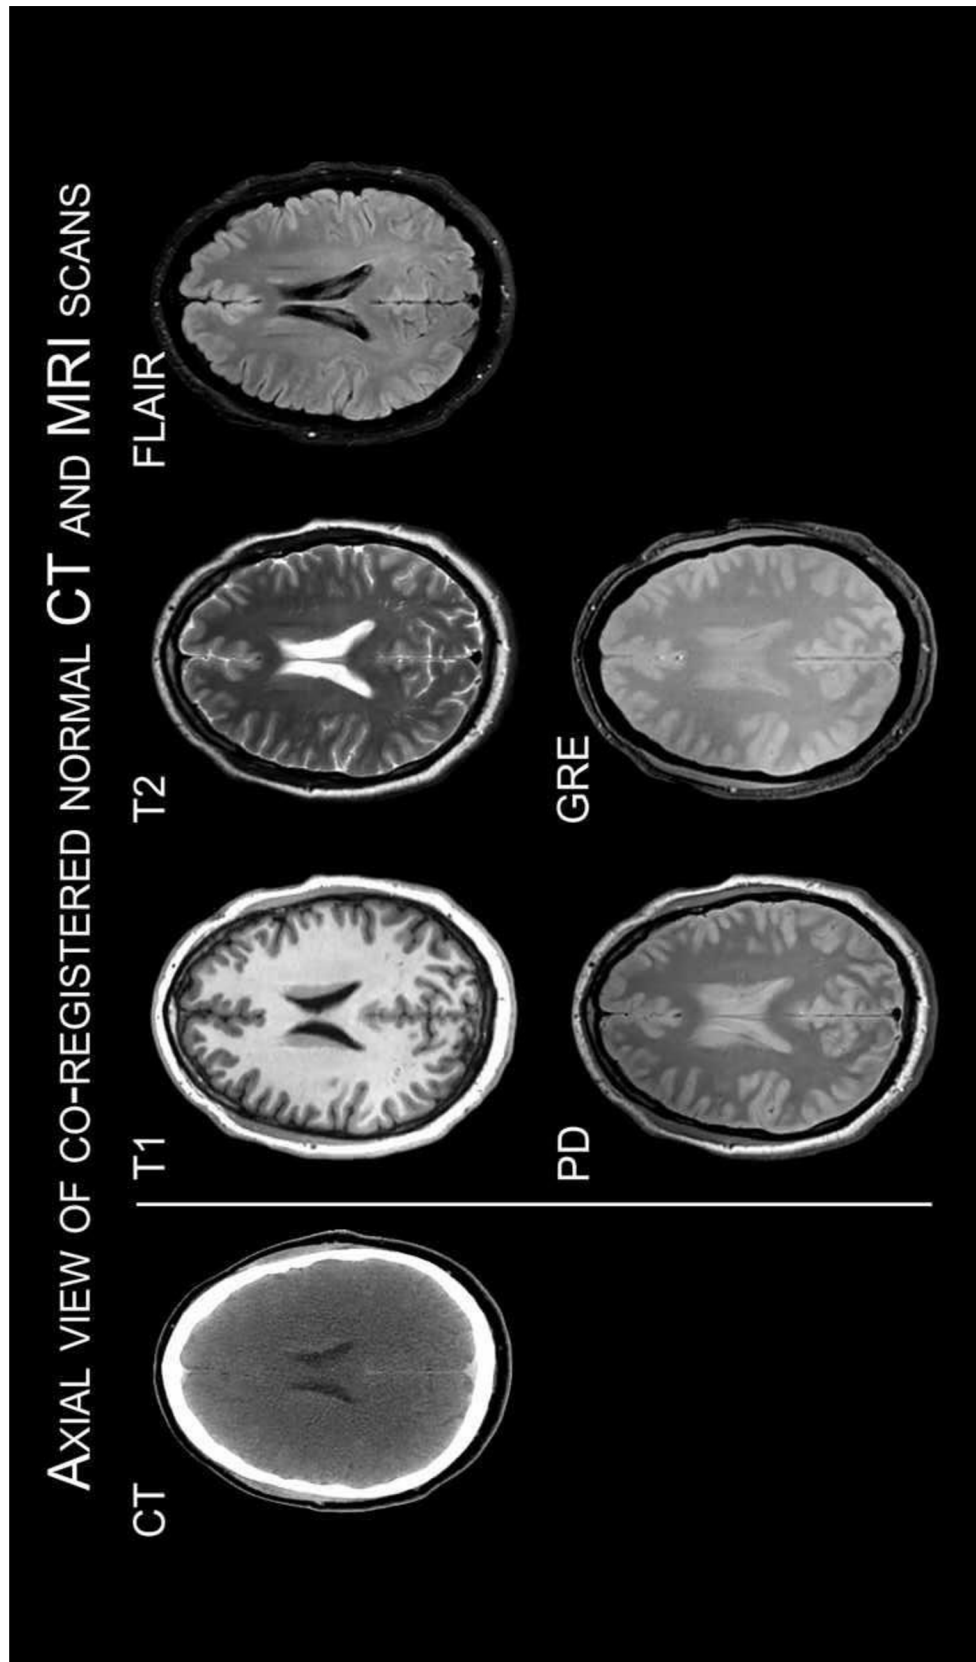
Comparison between axial view of CT scan and several MRI scans. Retrieved May 3, 2016 from <https://www.youtube.com/watch?v=sz0qd5q6FDU>
